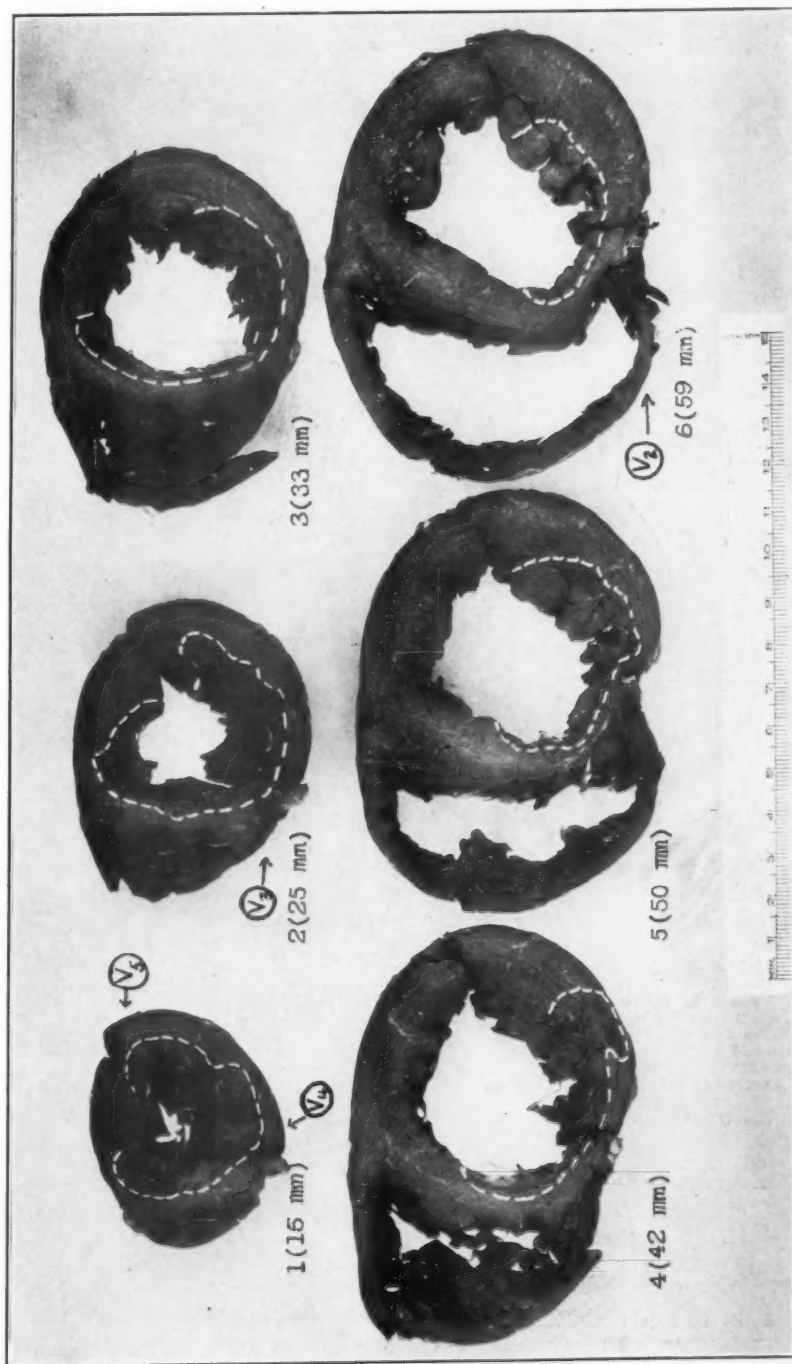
Case 2. Sections of the heart. The basal side of each section is seen, with the anterior wall below. The subendo-cardial extent of the infarct is outlined in white. The sections are numbered from apex to base. The figure in parentheses after each number indicates the distance in millimeters of that level from the apex. V_1 , V_2 , V_3 , V_4 , and V_5 show where a probe pierced the heart when introduced perpendicular to the chest wall at the following precordial points: V_1 , the upper angle made by the junction of the fifth left rib with the sternum; V_2 , fifth intercostal space in the left parasternal line; V_3 , fifth intercostal space in the left midclavicular line; V_4 , upper border of the sixth rib in the left anterior axillary line; V_5 , upper border of the sixth rib in the left anterior axillary line.
